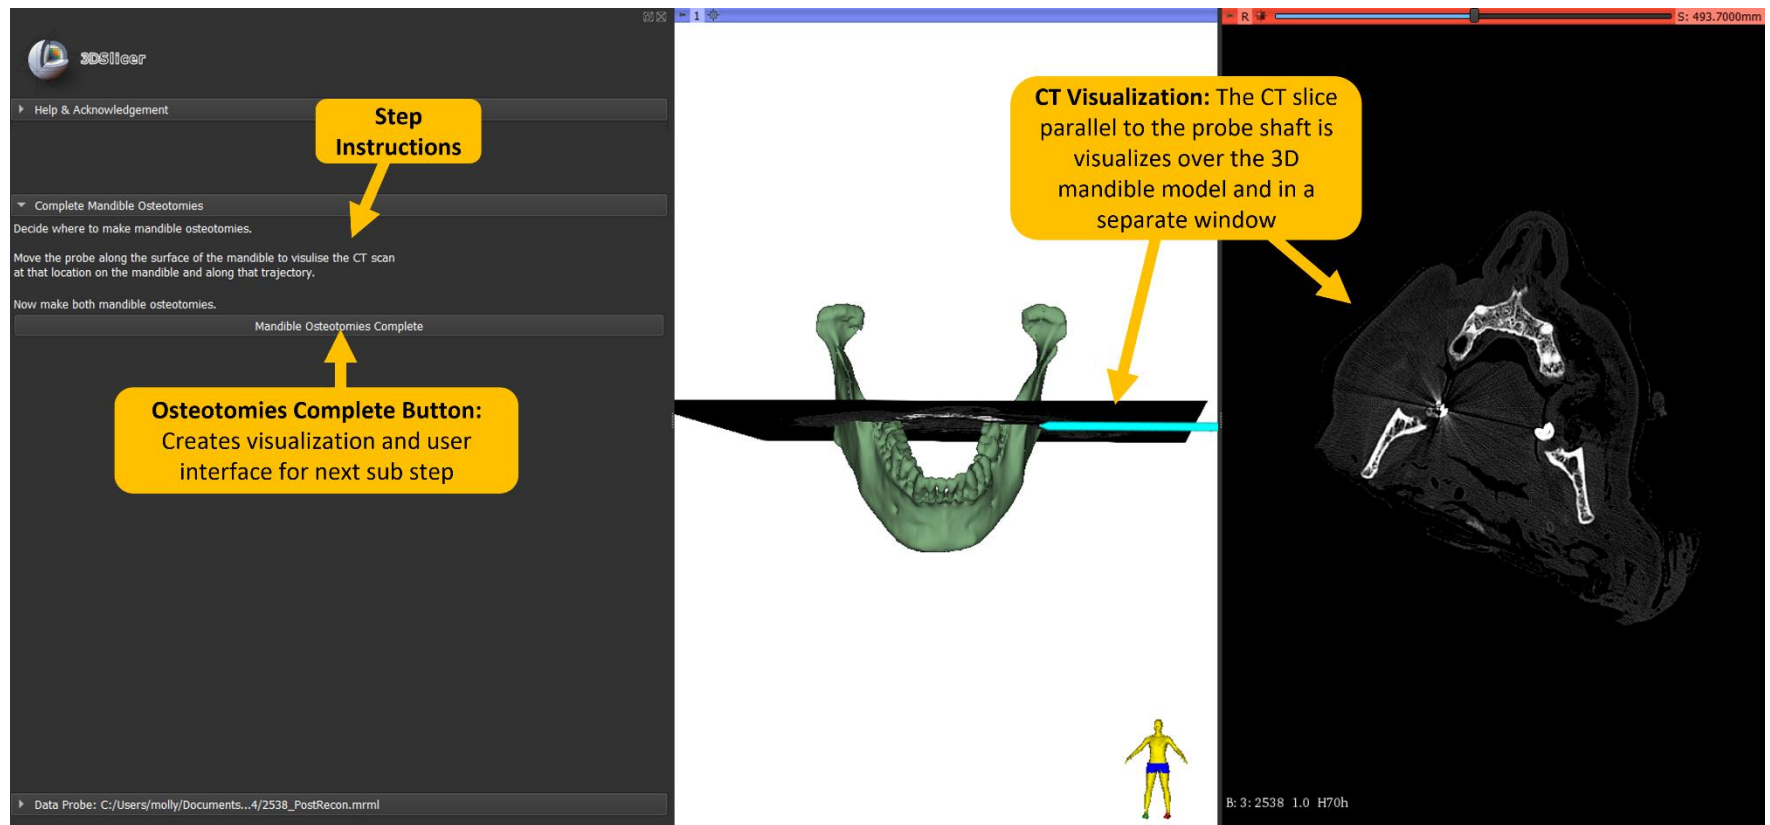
Visualize mandible CT user interface in 3D Slicer
